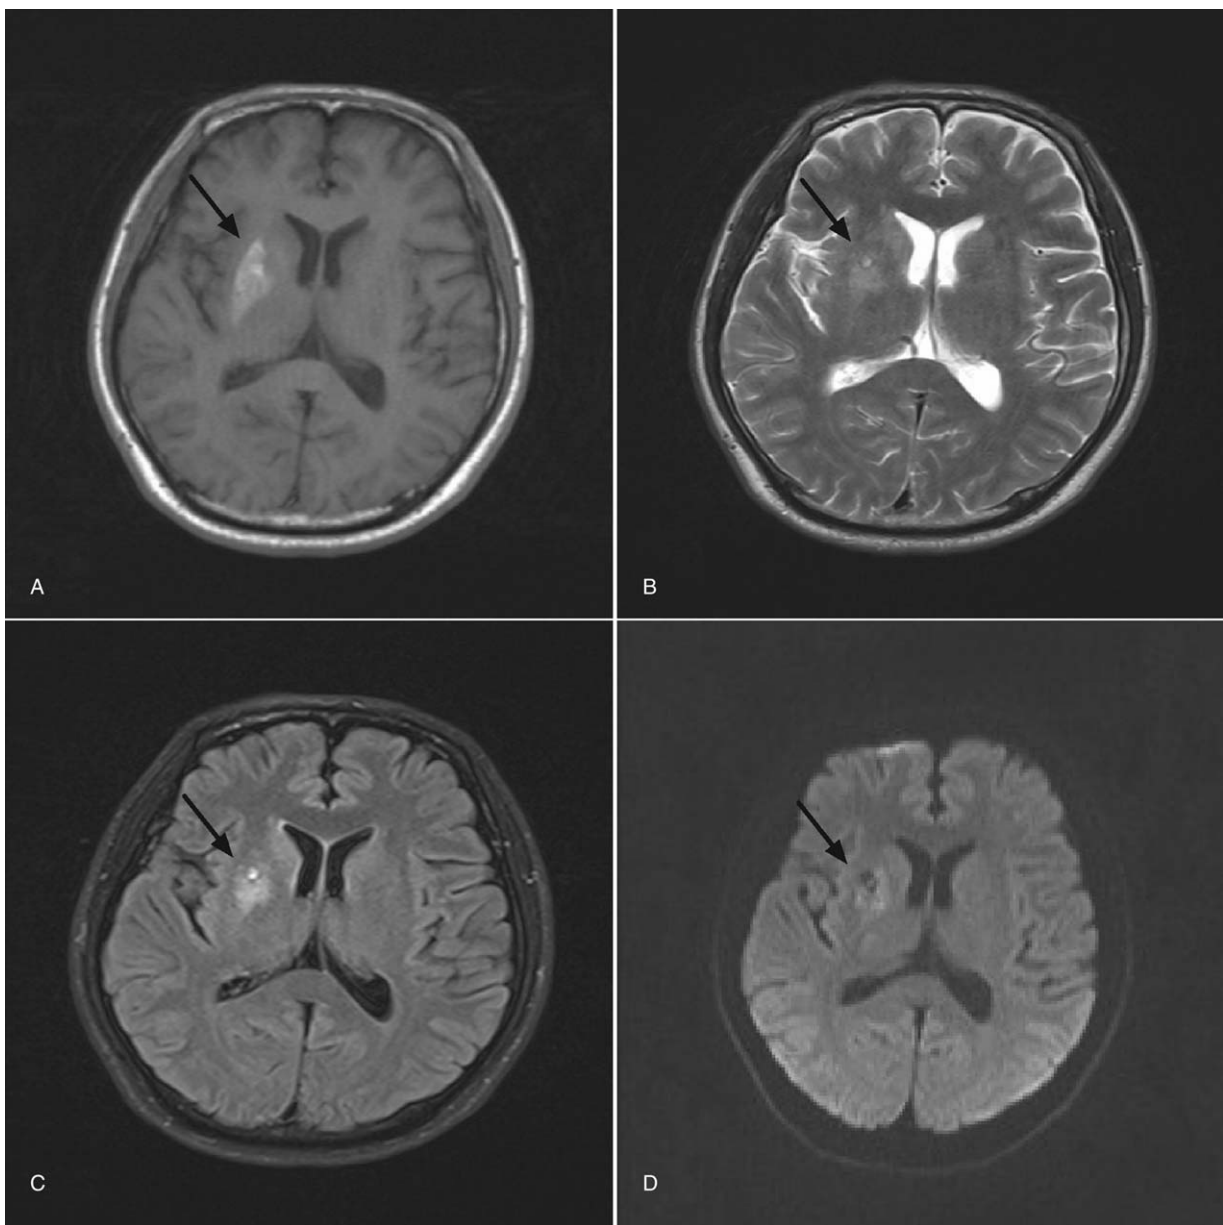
MRI one month after initial presentation showed a cavernous angioma and infarction in the right basal ganglia region on axial T1-(A) weighted, T2-(B) weighted, FLAIR (C) sequences, and DWI (D).
